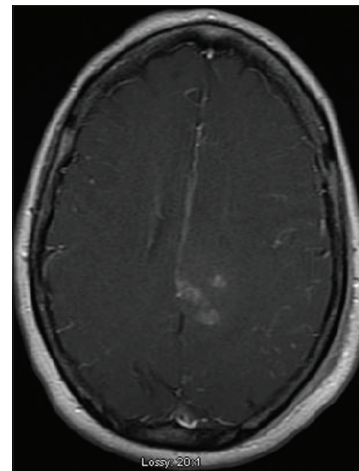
T1 with contrast MRI on postoperative day one
